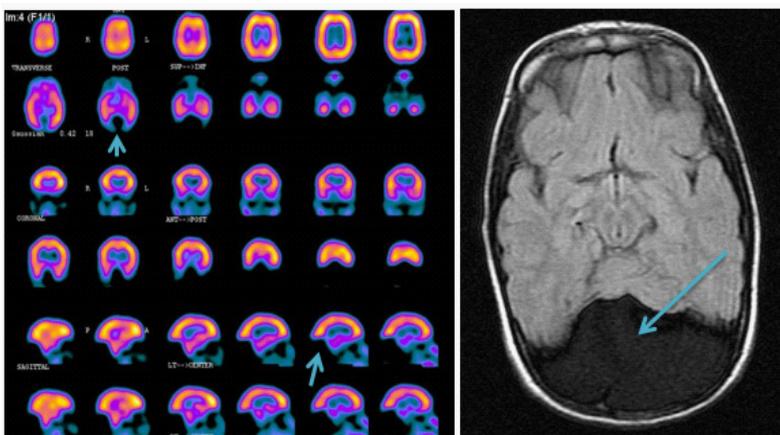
(2): Seizure in an 8-year-old female patient with Dandy walker cyst. SPECT scan: Absent rCBF in cerebellum .MRI: Large posterior fossa cyst communicating with the 4th ventricle with subsequent hypoplasia of the cerebellum and small rotated vermis (arrow).
